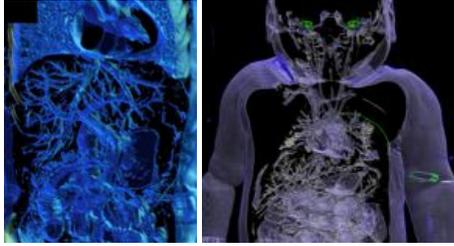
CT examinations were post-mortem gas in vessels can be used as a “negative” contrast agent. The stomach, intestines and the heart are filled with gas.
